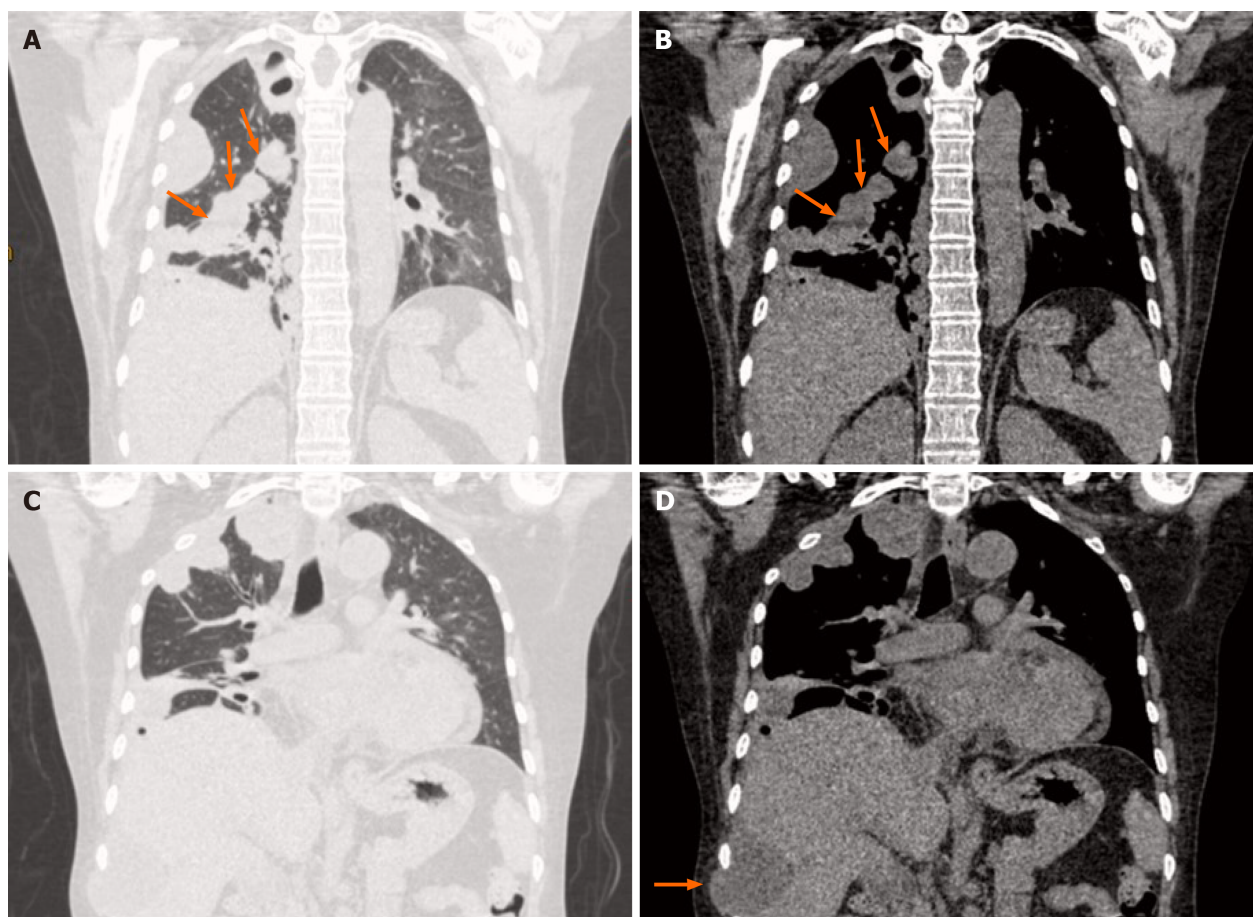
Coronal computed tomography showed many nodular or hillock lesions in the right pleura, mediastinum, and interlobar fissure areas. A and B: The lesions were located in the right pleura, mediastinum, and interlobar fissure areas (thin arrow); C and D: The lesions were located in the right pleura and mediastinum areas. On the lower layer, one lesion infiltrated the chest wall, and the adjacent liver was compressed (thick arrow).
